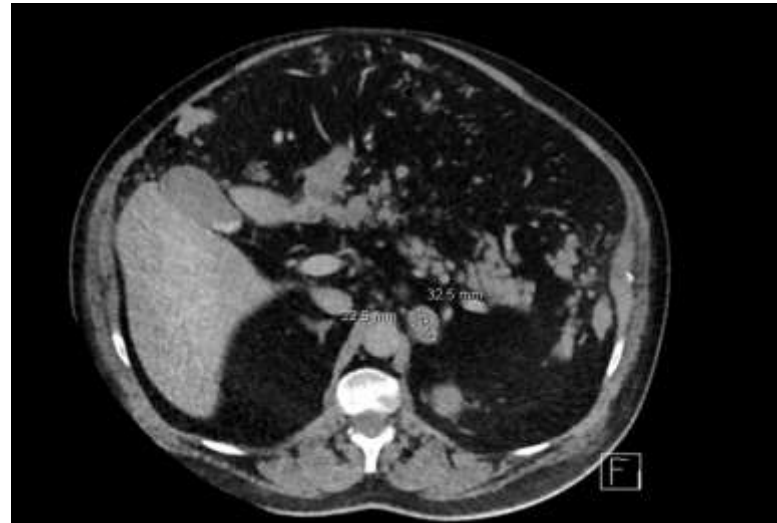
CT abdomen/ pelvis showing recurrent mass, 2.3x3.6cm in the left adrenal bed
